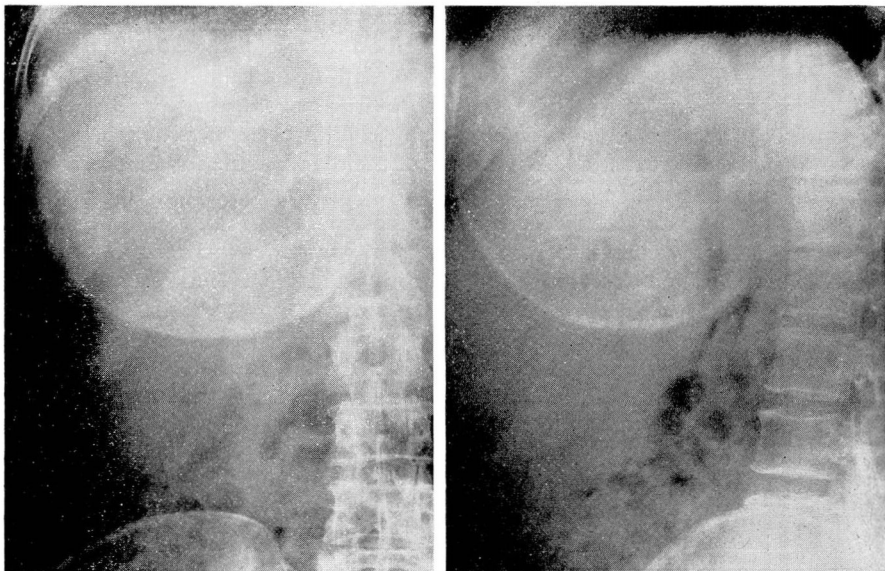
Postero-anterior and lateral roentgenograms demonstrating irregularly calcified mass in liver. Mass measured approximately 19 cm. in diameter on film.
